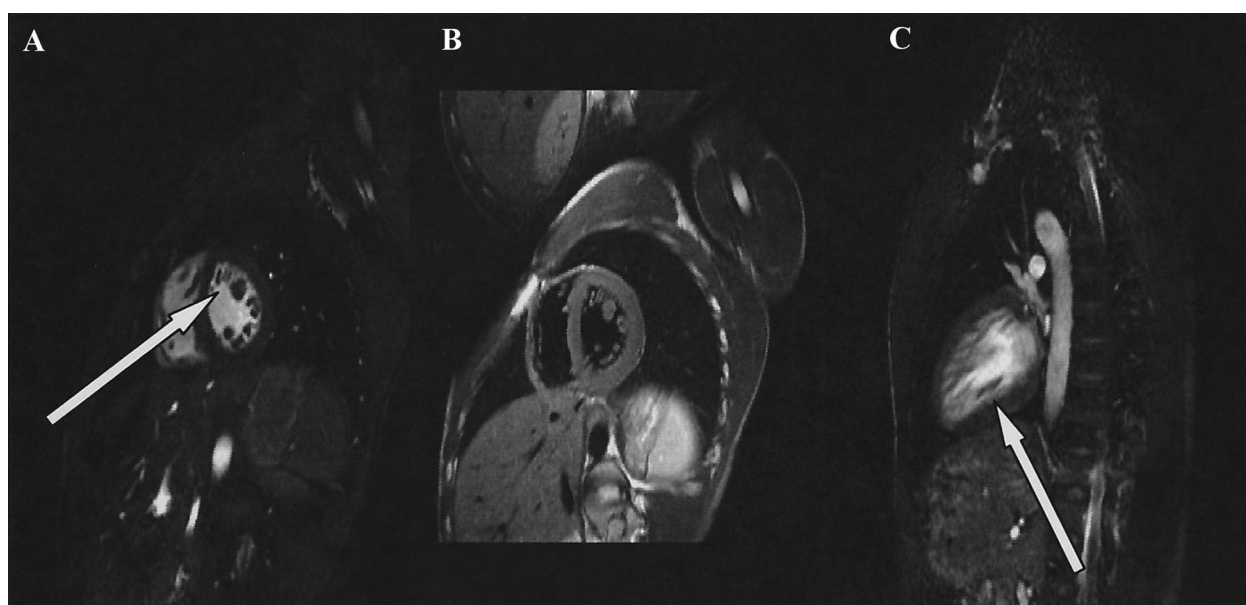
Magnetic resonance imaging (MRI) in a patient with ventricular noncompaction. Short axis (A), longitudinal (B) images, and sagittal MRI images (C) showing no thrombus but increased trabeculation of the left ventricle (white arrows).
